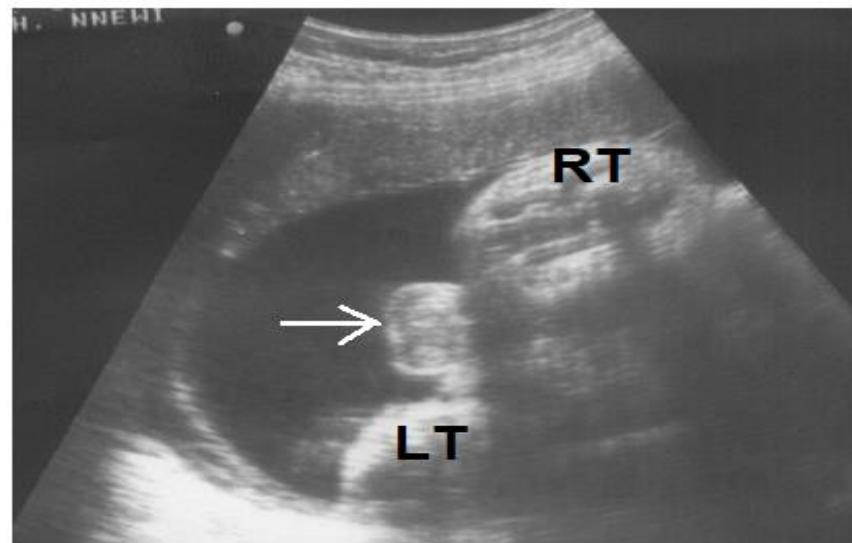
Sonogram showing the scrotum signifying a male sex of the foetus. Note the scrotum (arrow) protruding out into the amniotic fluid between both thighs (RT and LT)
